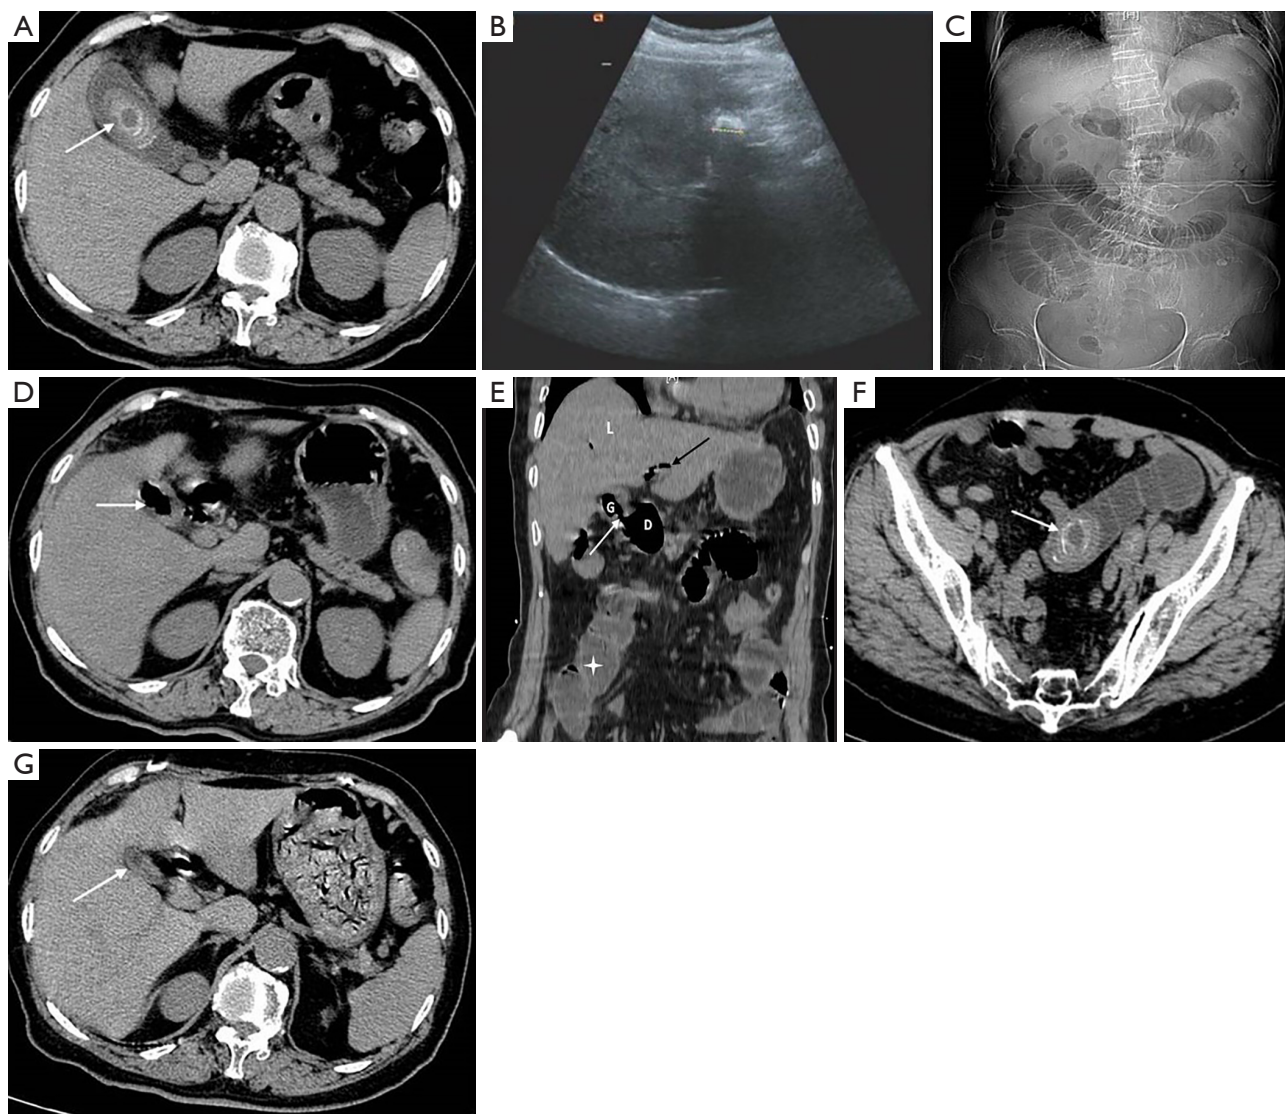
CT and US images of a CDF and the gallstone ileus (Case 1). (A) The previous axial CT image (1 year before admission) showed circular stones of mixed densities (white arrow) in the gallbladder. (B) The US image on admission showed an ill-defined gallbladder, with a strong echo light mass and sound shadow in the rear. (C) The plain film abdominal X-ray showed pneumatosis and dilatation of the intestine in the middle abdomen. (D) The axial CT image showed the gas accumulation (white arrow) in the gallbladder. (E) The coronal CT image clearly showed a fistula that formed between the gallbladder and duodenum (white arrow), along with intrahepatic bile duct pneumatosis (black arrow) and small intestinal effusion (asterisk). (F) The pelvic axial CT image showed a stone of mixed density (white arrow) in the small intestine and demonstrated bowel dilatation down to this level. (G) The follow-up axial CT image showed gallbladder atrophy (white arrow) and an absence of gas contained in either gallbladder or the biliary tract. G, gallbladder; D, duodenum; L, liver; CT, computed tomography; US, ultrasound; CDF, cholecystoduodenal fistula.
